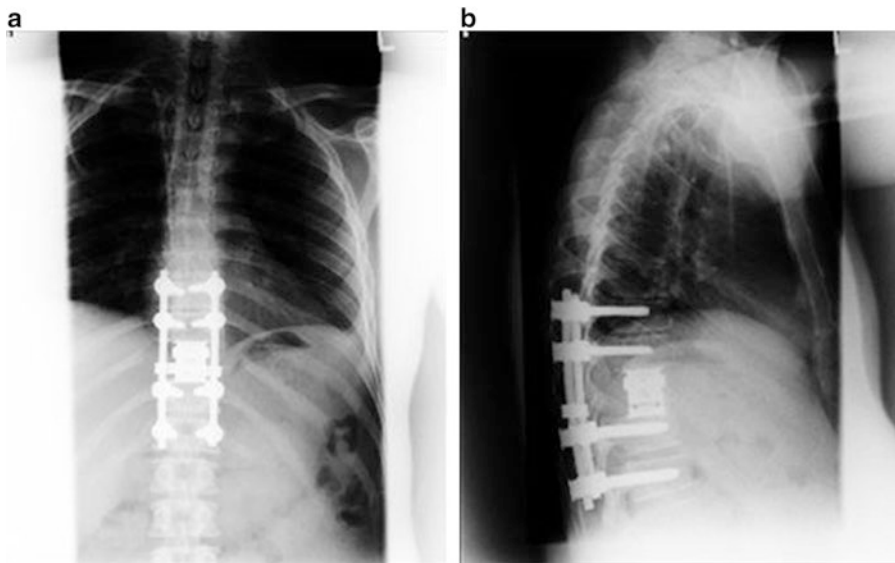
Case 1: (a) Postoperative anteroposterior; and (b) lateral radiographs
